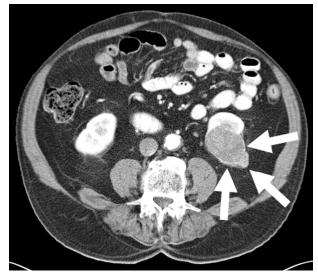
67-year-old man with renal cell carcinoma with paraneoplastic manifestations. Axial CT image of the abdomen shows a lobulated and heterogeneously enhancing mass arising from the lower aspect of the left kidney (arrows).
